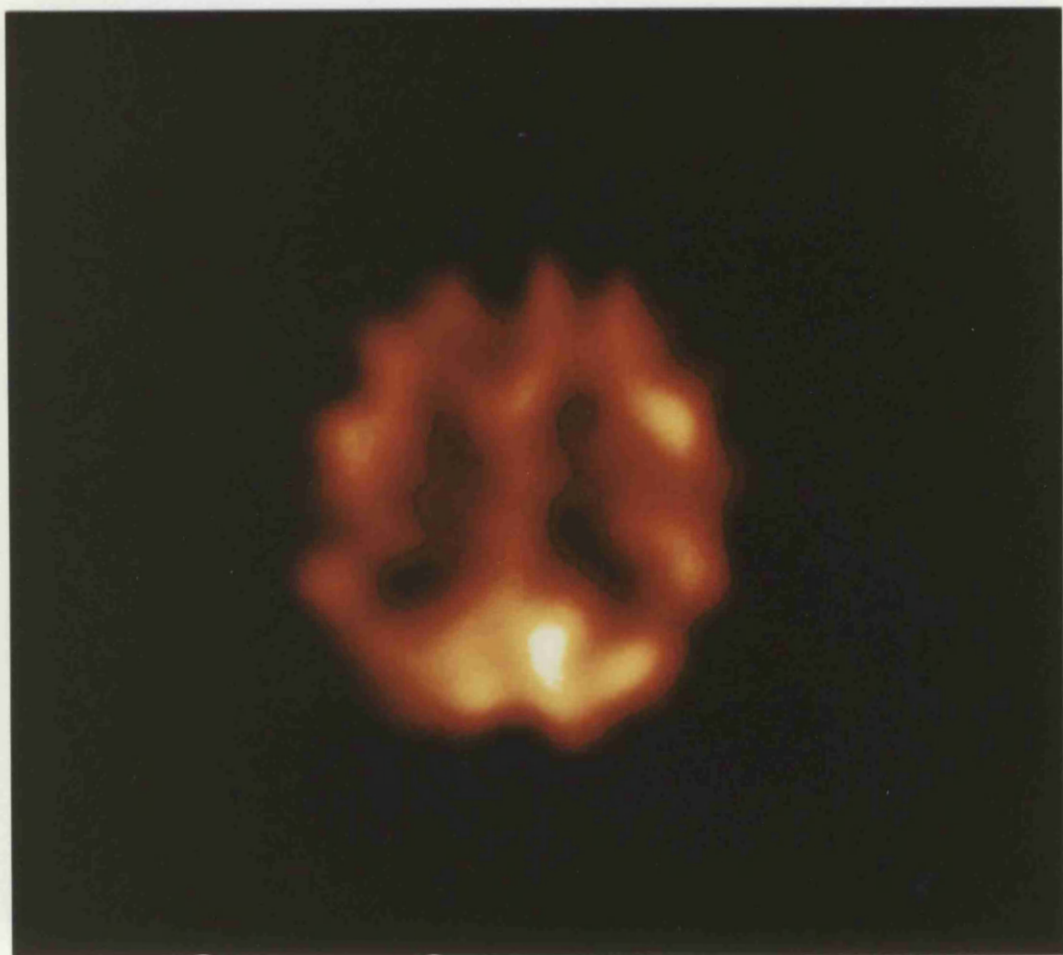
SPECT: Korsakoff's psychosis
